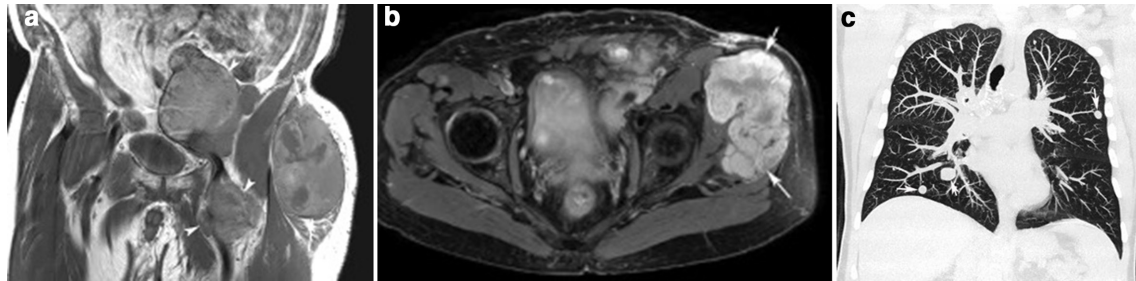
A 74-year-old male with a large mass in the left lateral buttock. (a) Coronal T_1 W TSE and (b) axial SPAIR MR images demonstrate a large (T3 AJCC stage) lobular soft tissue mass (arrows) with associated groin and external iliac lymphadenopathy (arrowheads-a) confirmed to be a high-grade extra skeletal myxoid chondrosarcoma on excision. (c) Coronal MIP chest CT study demonstrates multiple nodules (arrows), the largest measuring 17 mm consistent with metastases on both the >5 mm and >10 mm criteria. FSE, fast spin echo; IP, maximum intensity projection; PDW, proton density-weighted; TSE, turbo spin echo.
